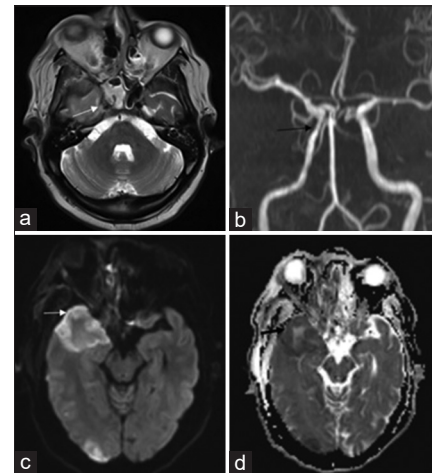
Mucormycosis with vascular and intracranial involvement. (a) Axial T2 weighted image shows mucosal thickening in sphenoid sinus with T2 hypointense lesion (necrotic tissue) involving right cavernous sinus with associated narrowing of cavernous segment of right internal carotid artery (white arrow), (b) Black arrow shows the narrowed and irregular cavernous and supraclinoid segment of right internal carotid artery, (c and d) Axial DWI and ADC images show restricted diffusion in right temporal and occipital lobe with ADC drop concerning for infarcts. DWI: Diffusion weighted imaging, ADC: Apparent diffusion coefficient, TOF: Time of flight
